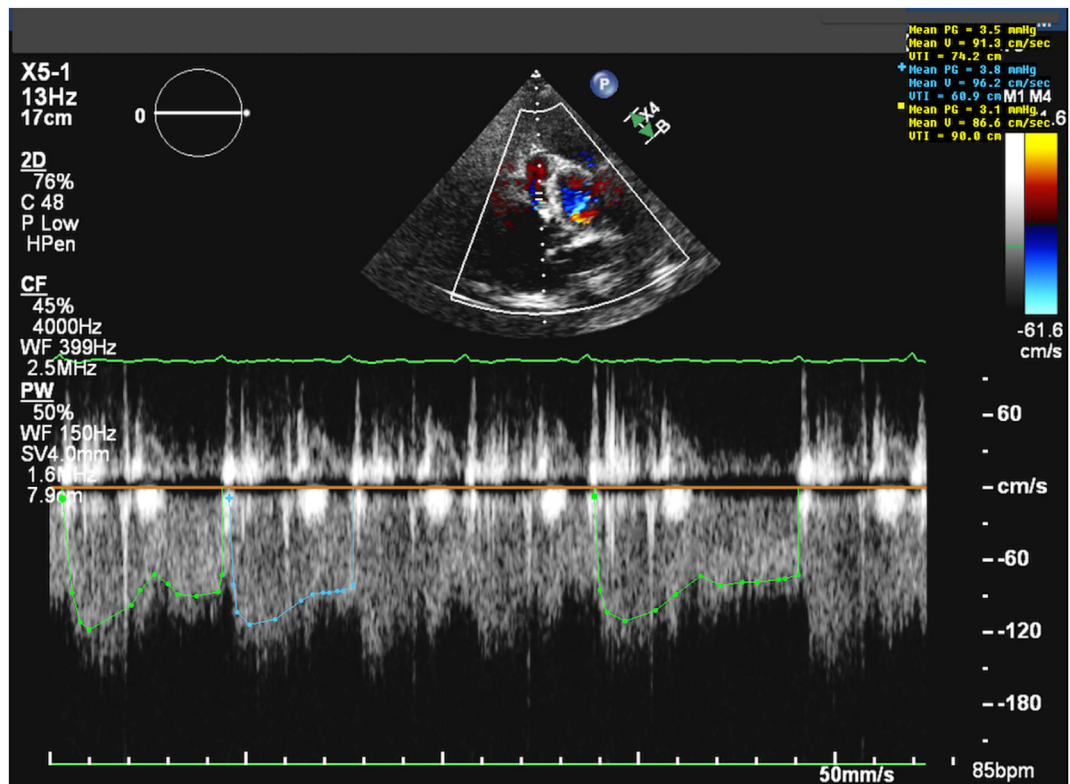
Two-dimensional TTE, modified parasternal basal short-axis view with color flow Doppler-guided pulsed-wave spectrum of the proximal fistula segment, demonstrates continuous flow, and averaging the modal flow velocity–time integral envelopes (*blue and green lines*) calculates a mean velocity–time integral of 75 cm. The fistula diameter at this Doppler measurement site was 1.1 cm, which calculates an estimated flow volume of 71 mL/beat.
